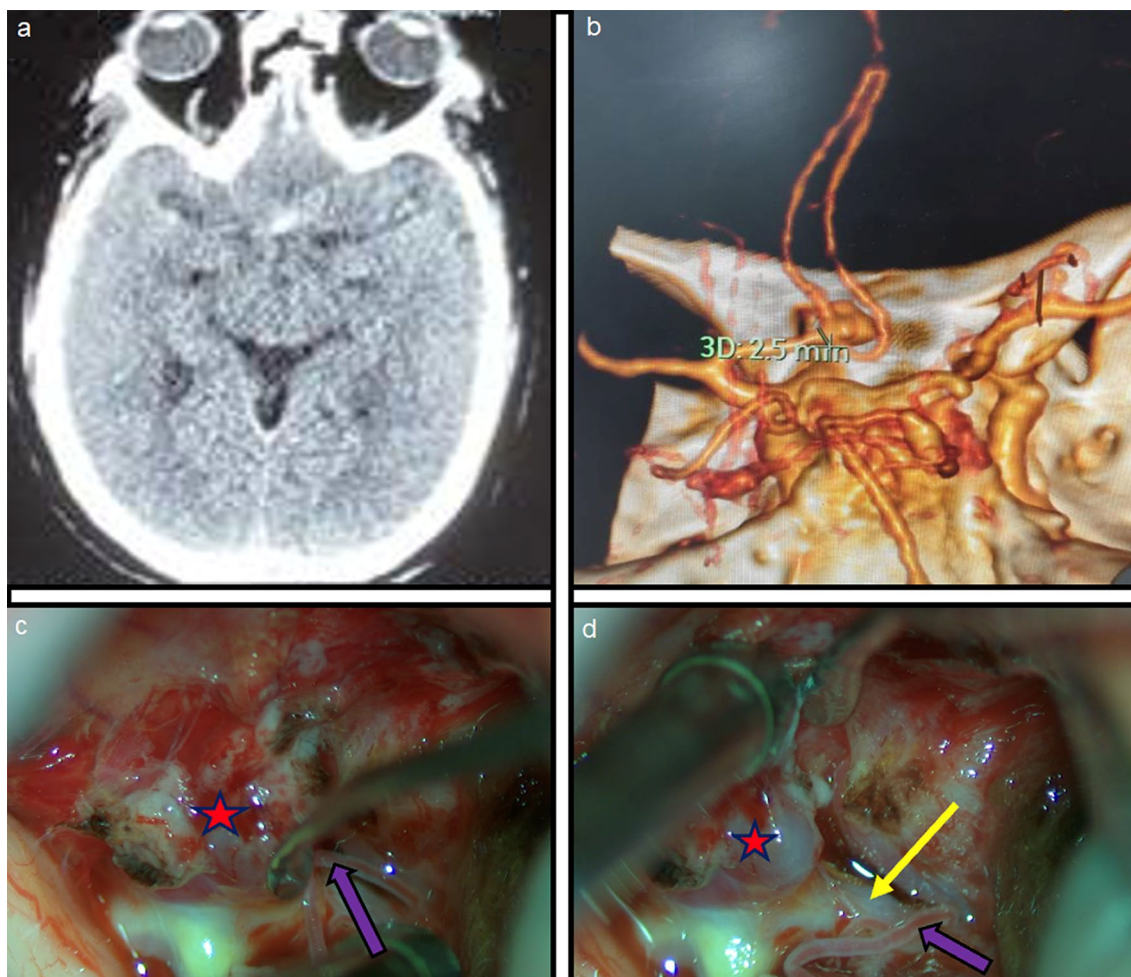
Plain CT scan head demonstrate small hyper density in the suprasellar cistern a. Reconstructed image of CT angiogram demonstrates an anteriorly directed A- comm artery aneurysm with bilobed appearance with dominant left A1 and right A1 is not visible b. Intraoperative images after left pterional craniotomy c and d demonstrates ipsilateral RAH (purple arrow) adhered to the neck of aneurysm (red star). After successful separation of the RAH from aneurysm the ipsilateral A2 (yellow arrow) is seen parallel to the opposite side of A2. In this case, RAH is arising from ipsilateral A2
